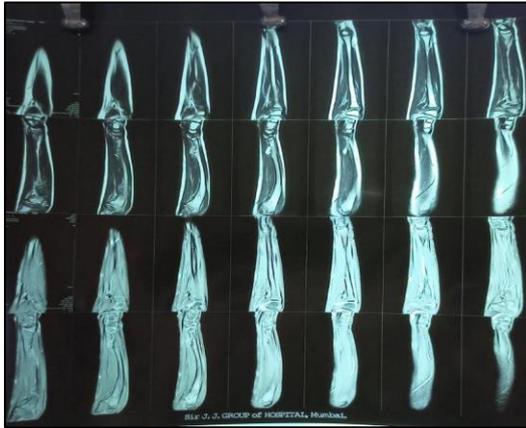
Distal ulna osteomyelitis MRI image sagittal view.
